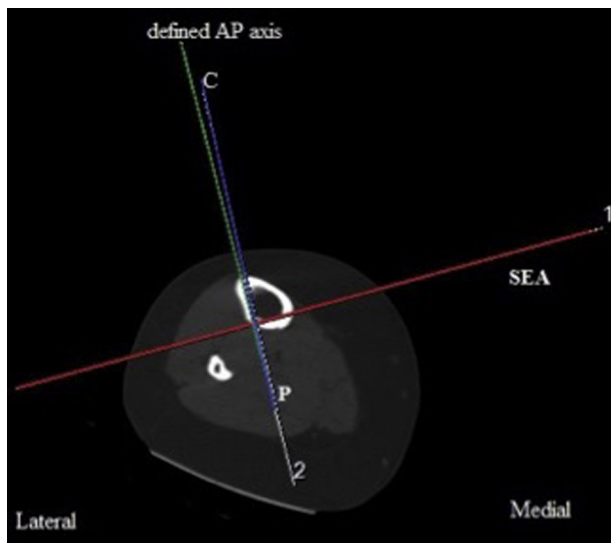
Axial CT image at the level of the proximal third of tibia in which angle C is the angle between the AP axis and the line connecting the most prominent point on the anterior border of tibia to PCL.
